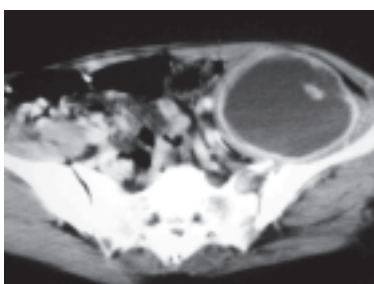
Enhanced axial CT scan taken at the level of the ilium.
